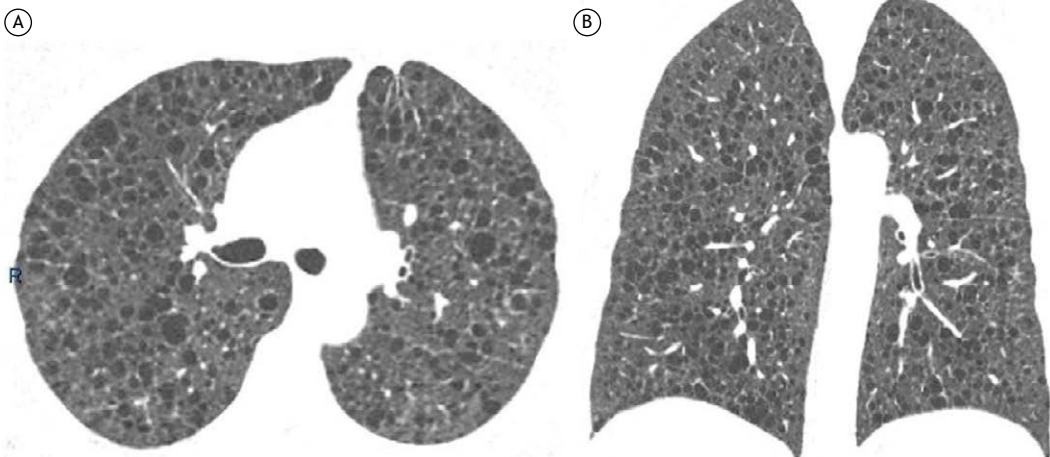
Axial (A) and coronal (B) CT scans with lung window settings revealing multiple pulmonary cysts in a female patient with lymphangioleiomyomatosis.
